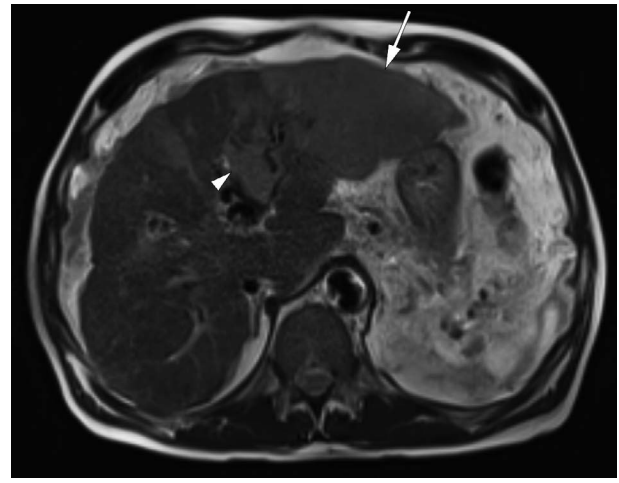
I-HCC. Annotated. Liver. MRI. T2 weighted. Single shot. Axial plane. An arrow points to I-HCC. An arrowhead points to tumor thrombus in the left portal vein.
